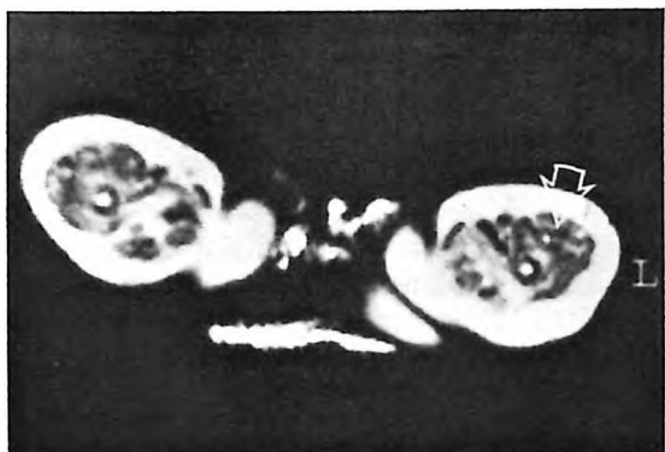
Two-year-old patient with merosin-deficient congenital muscular dystrophy CMD (Case 12). T2-weighted axial images of thigh muscles. Relative sparing of anterior thigh muscles compared to the posterior thigh muscles is noted (open arrow).
